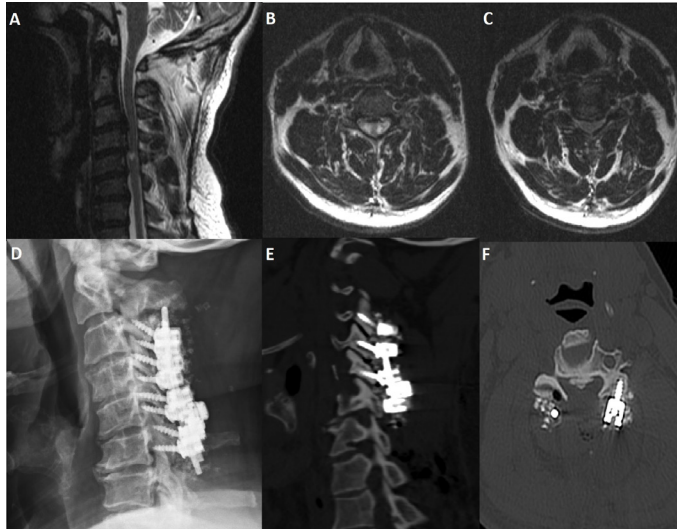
Loss of cervical lordosis, multi-level degenerative disc disease, cervical spinal stenosis and myelomalacia at C5 level can be seen T2-weighted sagittal and axial images (A, B, C). The patient underwent multi-level cervical laminectomy and lateral mass screw fixation surgery. O-arm imaging system was used to confirm screw placements intraoperatively. Plain radiography and computerized tomography images revealed that the screw placements were accurate (D, E, F)
